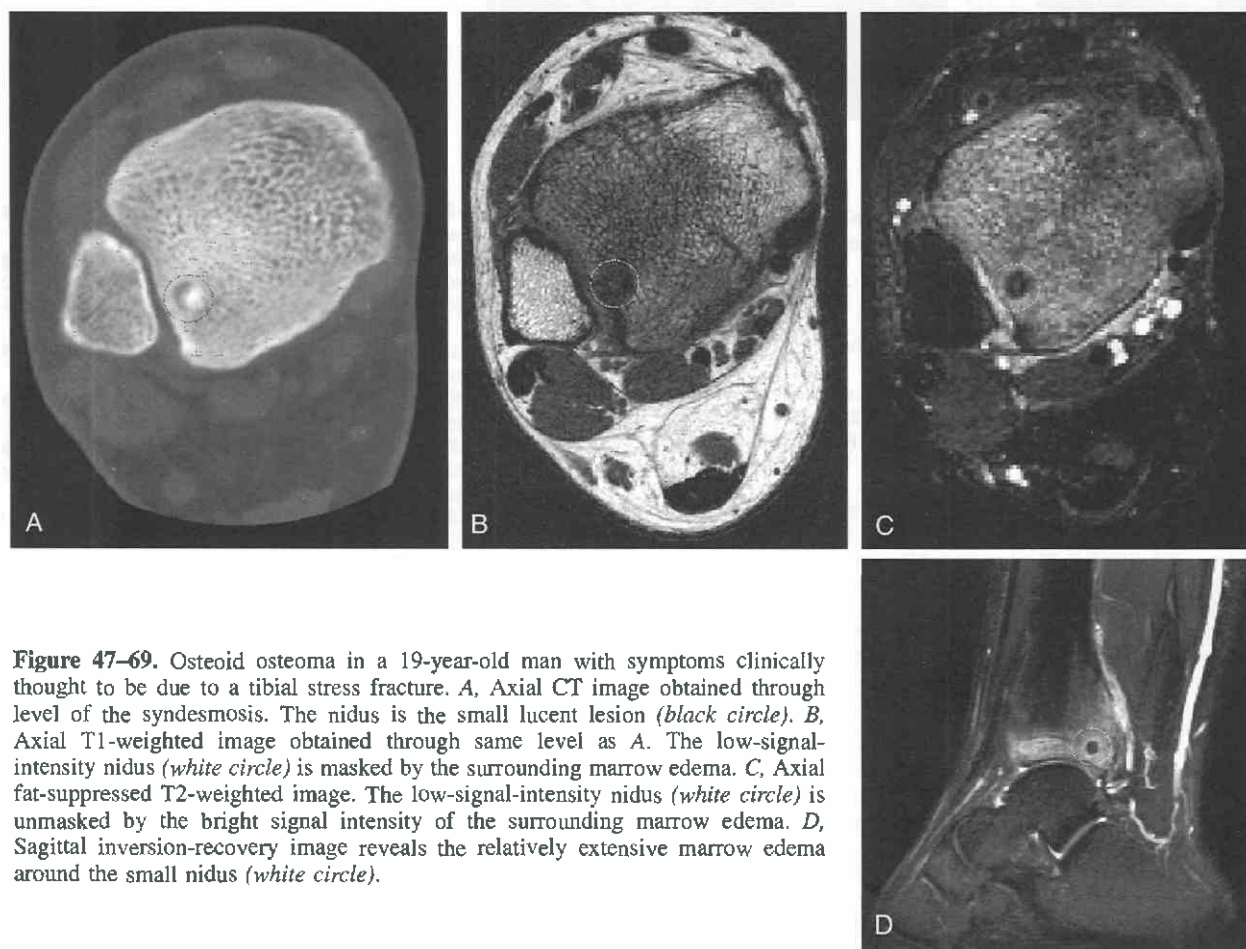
Osteoid osteoma in a 19-year-old man with symptoms clinically thought to be due to a tibial stress fracture. A, Axial CT image obtained through level of the syndesmosis. The nidus is the small lucent lesion (*black circle*). B, Axial T1-weighted image obtained through same level as A. The low-signal-intensity nidus (*white circle*) is masked by the surrounding marrow edema. C, Axial fat-suppressed T2-weighted image. The low-signal-intensity nidus (*white circle*) is unmasked by the bright signal intensity of the surrounding marrow edema. D, Sagittal inversion-recovery image reveals the relatively extensive marrow edema around the small nidus (*white circle*).
